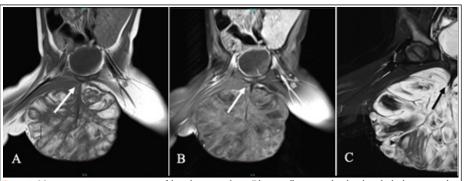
Magnetic resonance imaging scans of the pelvis, coronal cuts. Fibrous stalk associated with right ischial tuberosity can be seen (white/black arrows). (a) T1-weighted image showing heterogenous, encapsulated, lobulated mass with portions isointense to fat, (b) T1W, fat-suppressed image with portions isointense to muscle, and (c) contrast-enhanced T2W image showing high uptake and no signs of intrapelvic extension.
